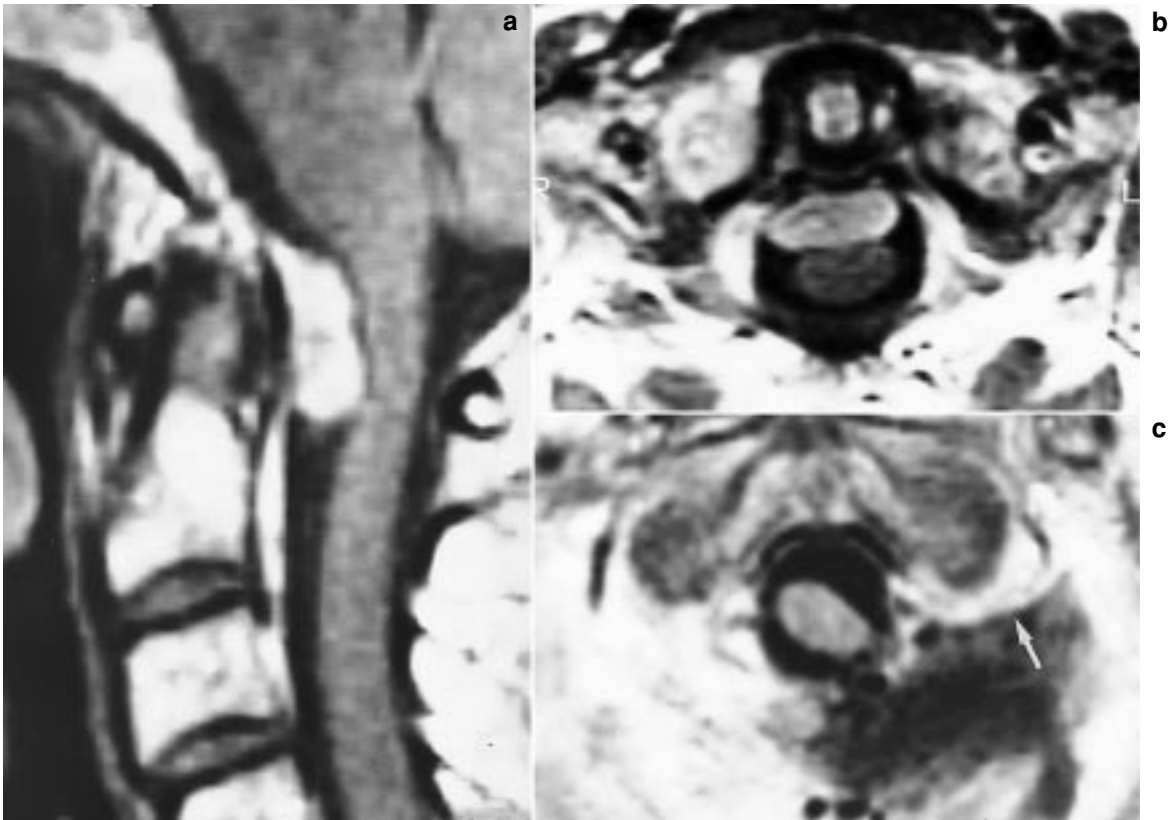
Anterior meningeoma of the foramen magnum. (a) Pre-operative sagittal view. (b) Pre-operative axial view. (c) Post-operative MRI. The arrow indicates the vertebral artery running around the intact condyle
